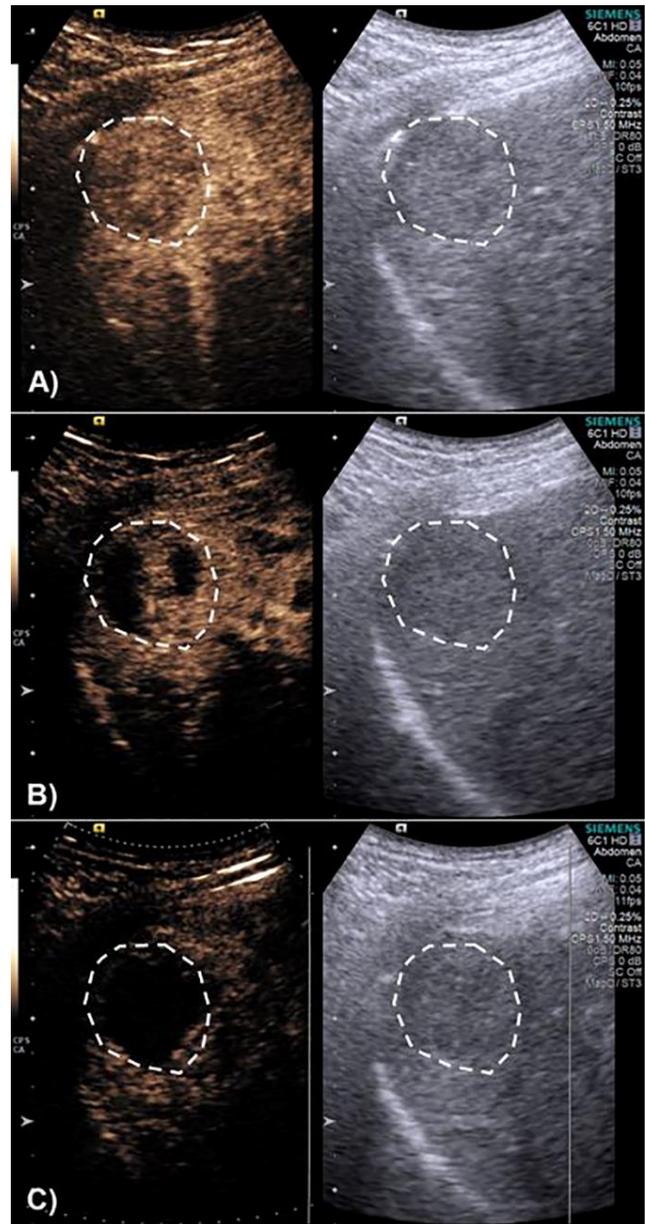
Representative CEUS images of a CR patient from all 3 study time points, left image is CEUS, right image is grayscale ultrasound. A) CEUS imaging immediately following radioembolization, with the entire tumor region showing echogenicity. B) CEUS imaging at 7 days post-treatment, with small hypoechoic regions within the tumor suggesting necrotic tissue. C) CEUS imaging at 14 days post-treatment, with most of the tumor area appearing hypoechoic suggesting mostly necrotic tissue.
